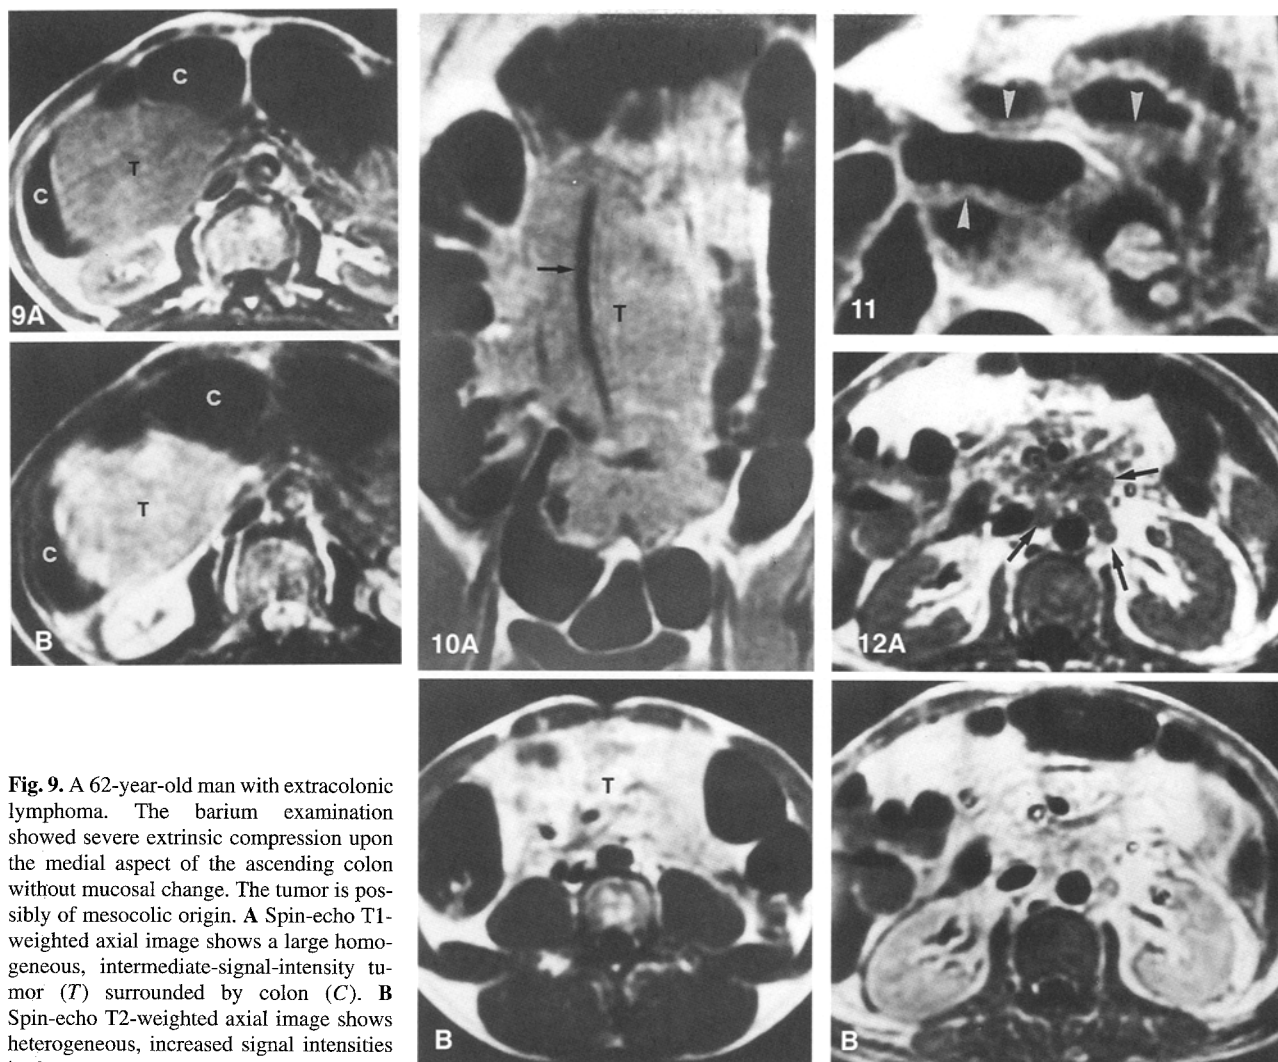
Spin-echo T1-weighted (A) pre- and (B) post-gadolinium-enhanced axial images of a 51-year-old woman with gastric and jejunal
